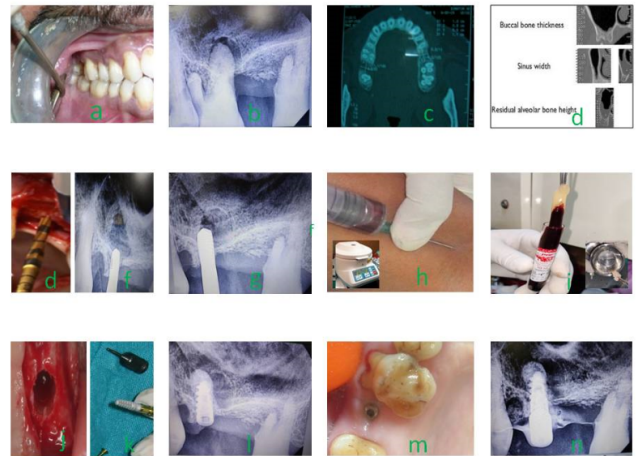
a. preoperative; b: preop xray; c: preop CT Scan; d: Residual bone height; e: First Densah™ Bur; f: Xray-first Bur position; g: Xray-Sequential bur in densifying mode; h: PRF & centrifuge protocol; i: sticky bone prepared; j: Final width osteotomy; k: Implant planned; l: Implant inserted; m: postoperative; n: Healing abutment for prosthesis.
